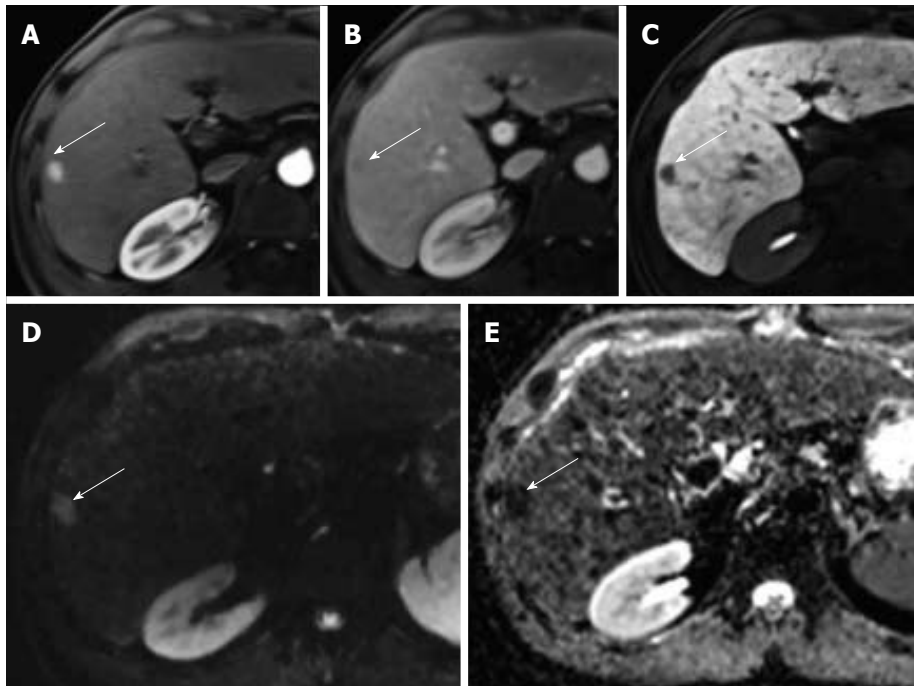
Typical characteristics of a hepatocellular carcinoma. A small lesion in segment 6 demonstrates arterial enhancement (A), washout in the portal venous phase (B), hypointensity in the hepatobiliary phase (C) and restricted diffusion [hyperintense on DWI (D) and hypointense on ADC (E)].
